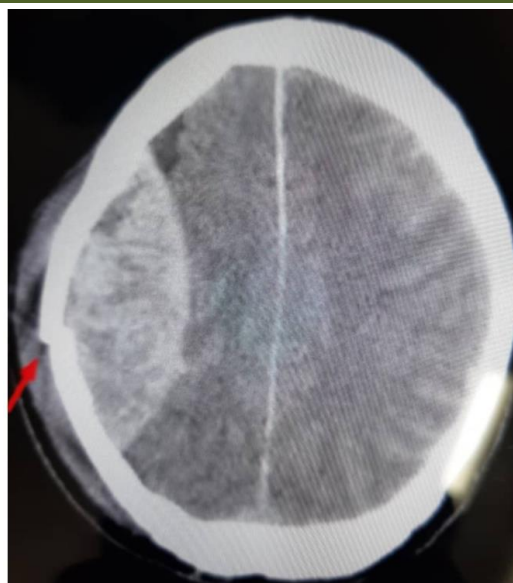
Axial CT scan without injection showing a fresh hematoma in a compressive right parietal biconvex lens on the cerebral parenchyma next to a focus of ipsilateral parietal fracture and subgaleal hematoma
